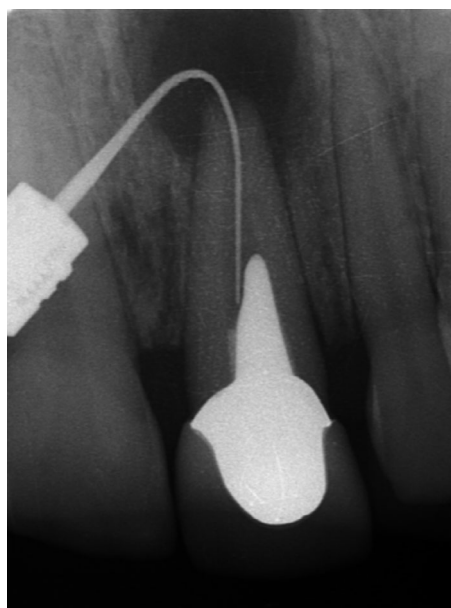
An example of a retrograde preparation extending coronally as deeply as possible: Tooth No. 21, pre-bent No. 35 ultrasonic file.
